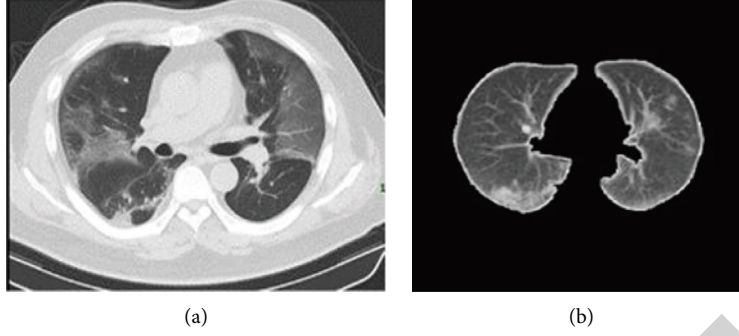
CT lung classification: (a) original CT lung case and (b) segmented CT lung.
